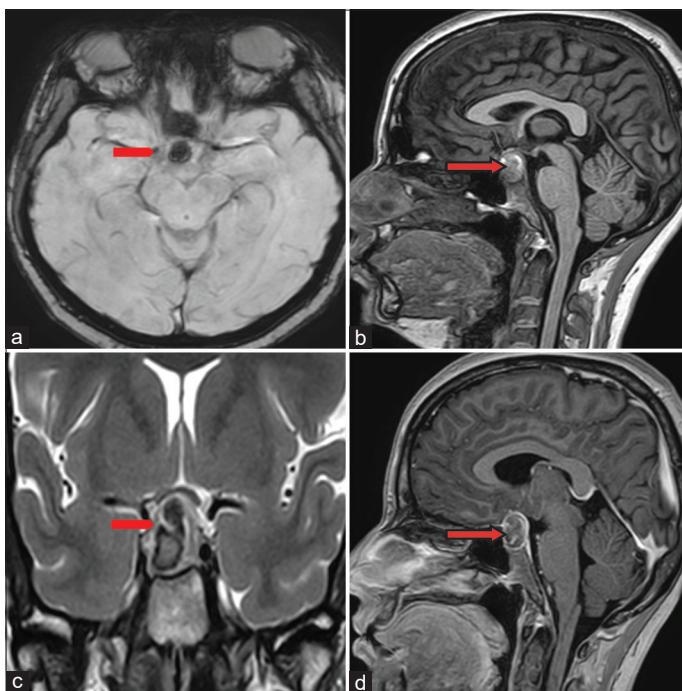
MRI images of the patient (a) AXIAL SWI; (b) SAGITTAL T1; (c) CORONAL T2; and (d) SAGITTAL T1
